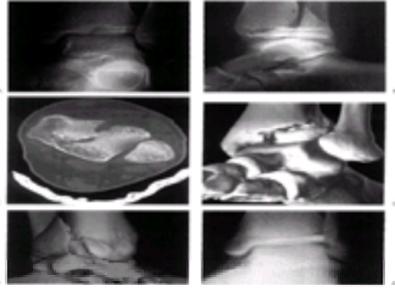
Triplane fracture of the distal tibia in a 12-year-old girl. A: The anteroposterior radiograph shows a Salter-Harris type III fracture. B: The lateral radiograph shows an apparent Salter-Harris type II fracture. This indicates a triplane injury. C: Computed tomography through the epiphysis confirms a two-part fracture. D and E: Three-dimensional reconstruction demonstrates the fracture from the anterolateral and posteromedial views. F: Closed reduction was unsuccessful. Arthroscopically assisted open reduction was performed. The fracture was stabilized with a single anterolateral cannulated screw inserted percutaneously.
